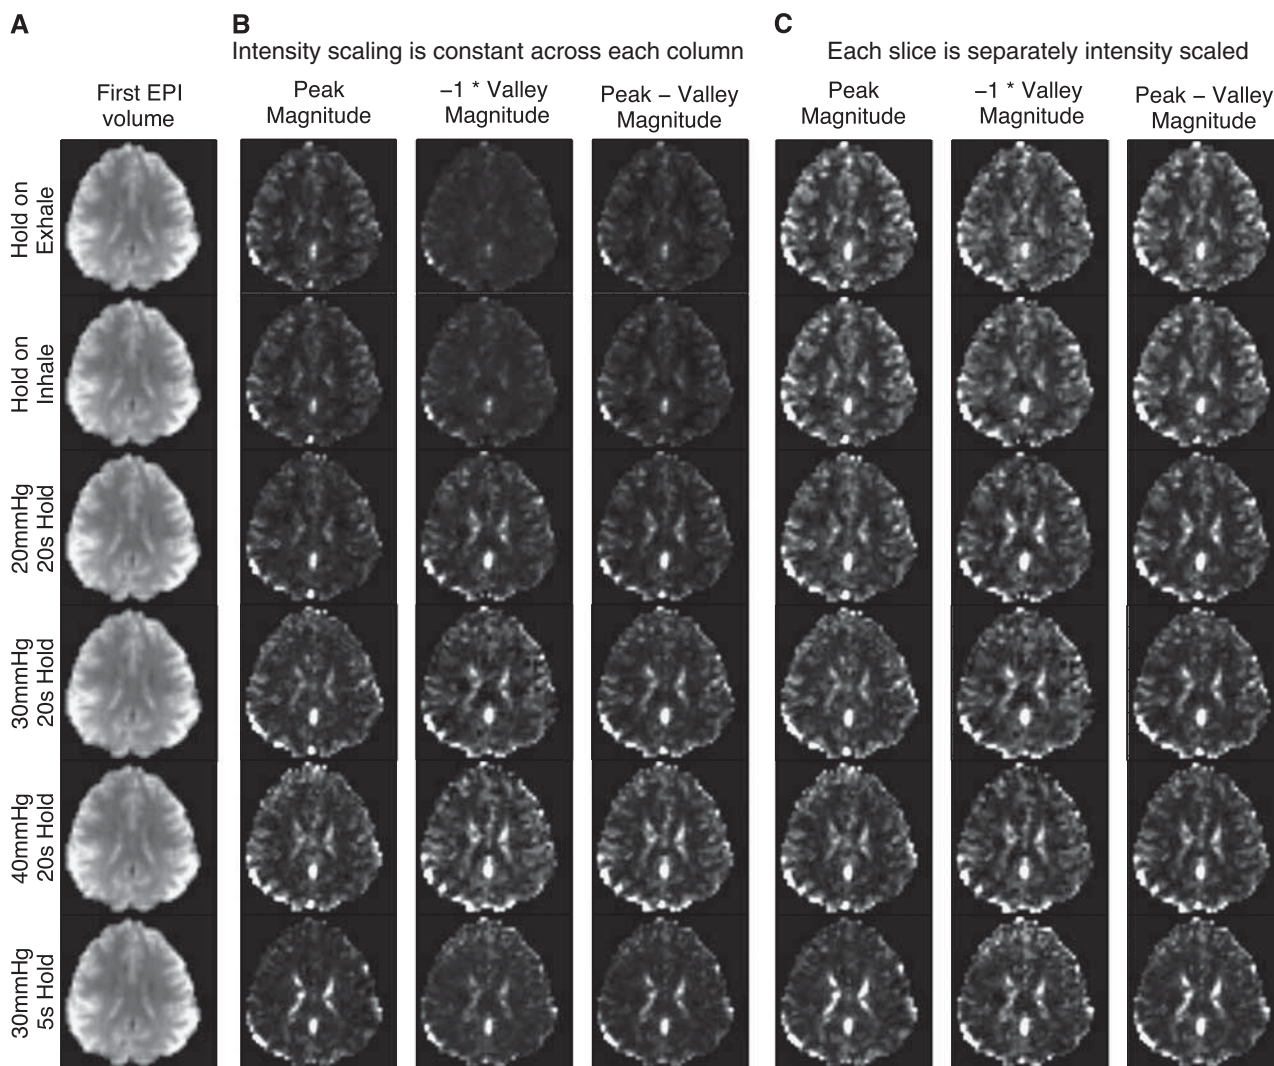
Comparison of magnetic resonance imaging (MRI) signal magnitudes during breath holding and Valsalva conditions. The intensity scale of runs from 2% (black) to 98% (white) of the cumulative distribution of the magnitudes. (A) The first EPI volume of each run. (B) The intensity scale is constant across each column. The raw magnitudes change within trial type, but the relative tissue contrast remains similar. (C) The intensity scale is calculated separately for each slice. The maps of peak magnitude, $-1 \times$ valley magnitude, and the difference between peak and valley magnitudes appears similar across breath hold and Valsalva conditions, even when the Valsalva maneuver duration is only 5 seconds.
